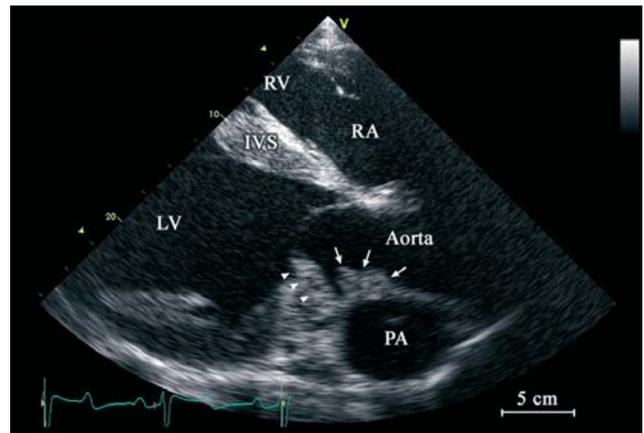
On cardiac ultrasound of the left ventricular outflow tract, a large vegetation is seen on the aortic valve cusps (arrow heads) and at the sinus of Valsalva (arrows). RA: right atrium; RV: right ventricle; IVS: interventricular septum; LV: left ventricle; PA: pulmonary artery. The displayed depth is 26 cm and dorsal is to the right of the image. The image is taken at end-diastole.
